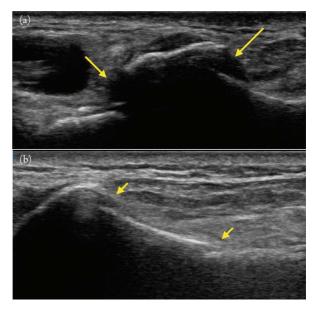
(a) Comminuted distal radius fracture on ultrasound. A longitudinal grayscale sonographic image of the distal forearm shows focal disruption of the linear echogenic bone cortex of the distal radius (arrows). Note the smooth normal linear echogenic bone cortex of the radius proximal and distal to the fracture site. (b) Fracture after reduction on ultrasound. During a reduction procedure, it is often difficult to assess successful reduction given surrounding tissue edema. The use of point-of-care ultrasound can allow the clinician to visualize the relative distance between fractured segments. Once adequate reduction is achieved, sedation can be discontinued, the fracture splinted, and confirmatory radiographs can be obtained.
